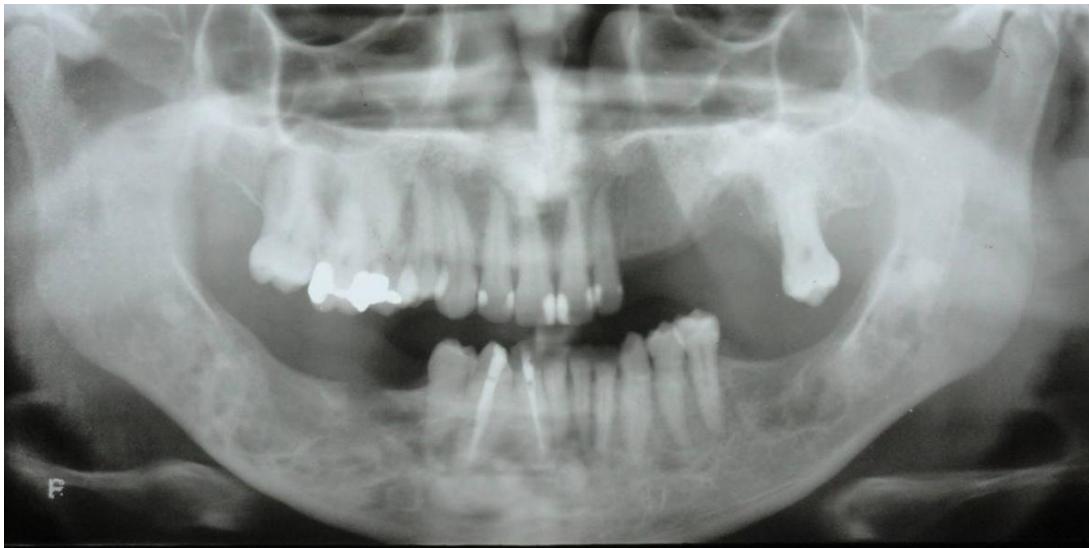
Panoramic radiograph (2002). Different pattern compared to previous radiographs showing more radiolucent areas in the mandibular body left and right sides.
